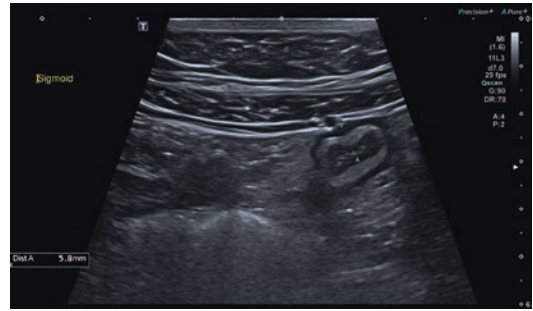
Ulcerative colitis intestinal ultrasound findings: thickened sigmoid bowel wall to 5.8 mm
